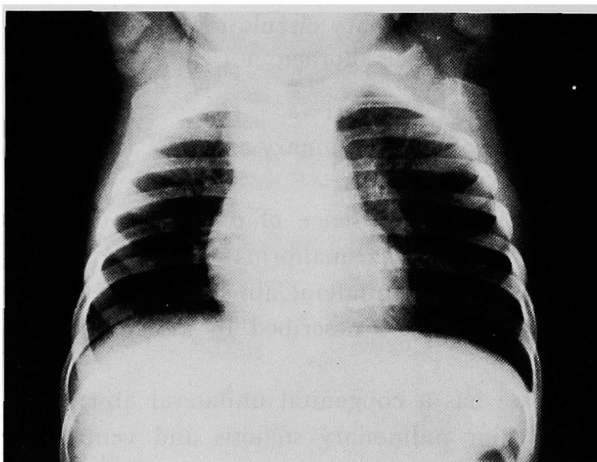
Chest X-ray in the postero-anterior view. The heart is slightly enlarged due to an enlargement of the right cavities. Increased main pulmonary artery branches and strikingly diminished right lung vascular markings. Right aortic arch. Right lung smaller than the left one.
